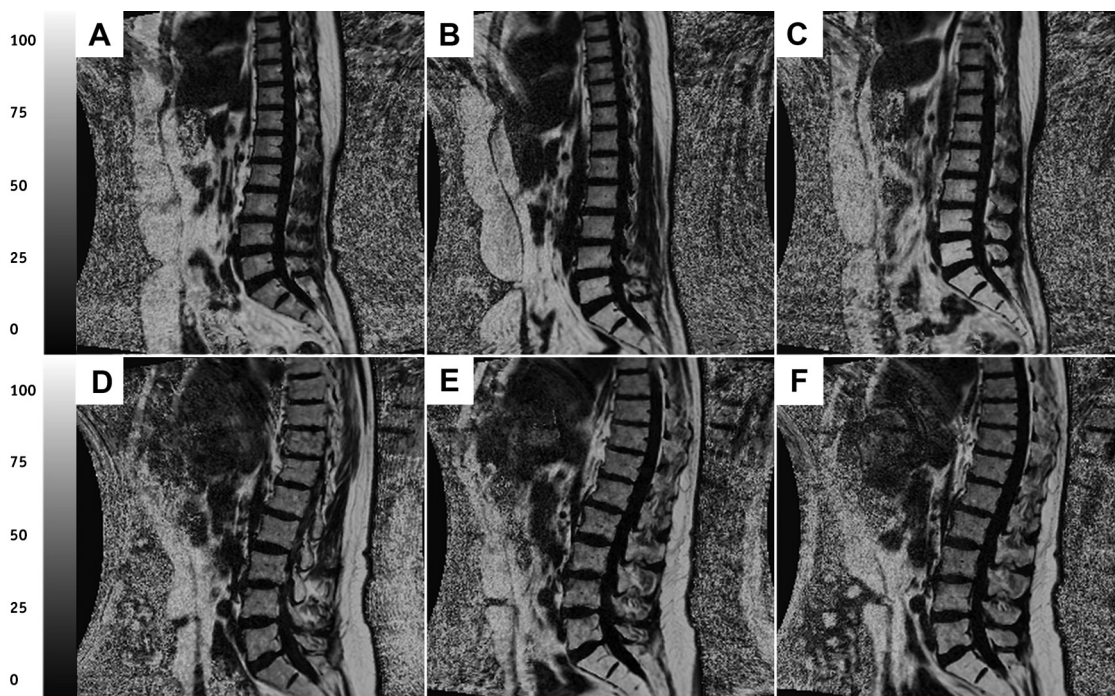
(A-C) MRIs from a subject with cervical cancer who received cisplatin chemotherapy and IMRT. (D-F) MRIs from a subject with prostate cancer who received IMRT alone. (A and D) Baseline results; (B and E) midtreatment; (C and F) immediately after treatment. PDFF(%) values for L5 regions of interest are (A) 59.4%, (B) 78.5%, (C) 92.1%, (D) 59.5%, (E) 65.8%, and (F) 63.8%. IMRT = intensity modulated radiation therapy; MRI = magnetic resonance imaging; PDFF = proton density fat fraction.
